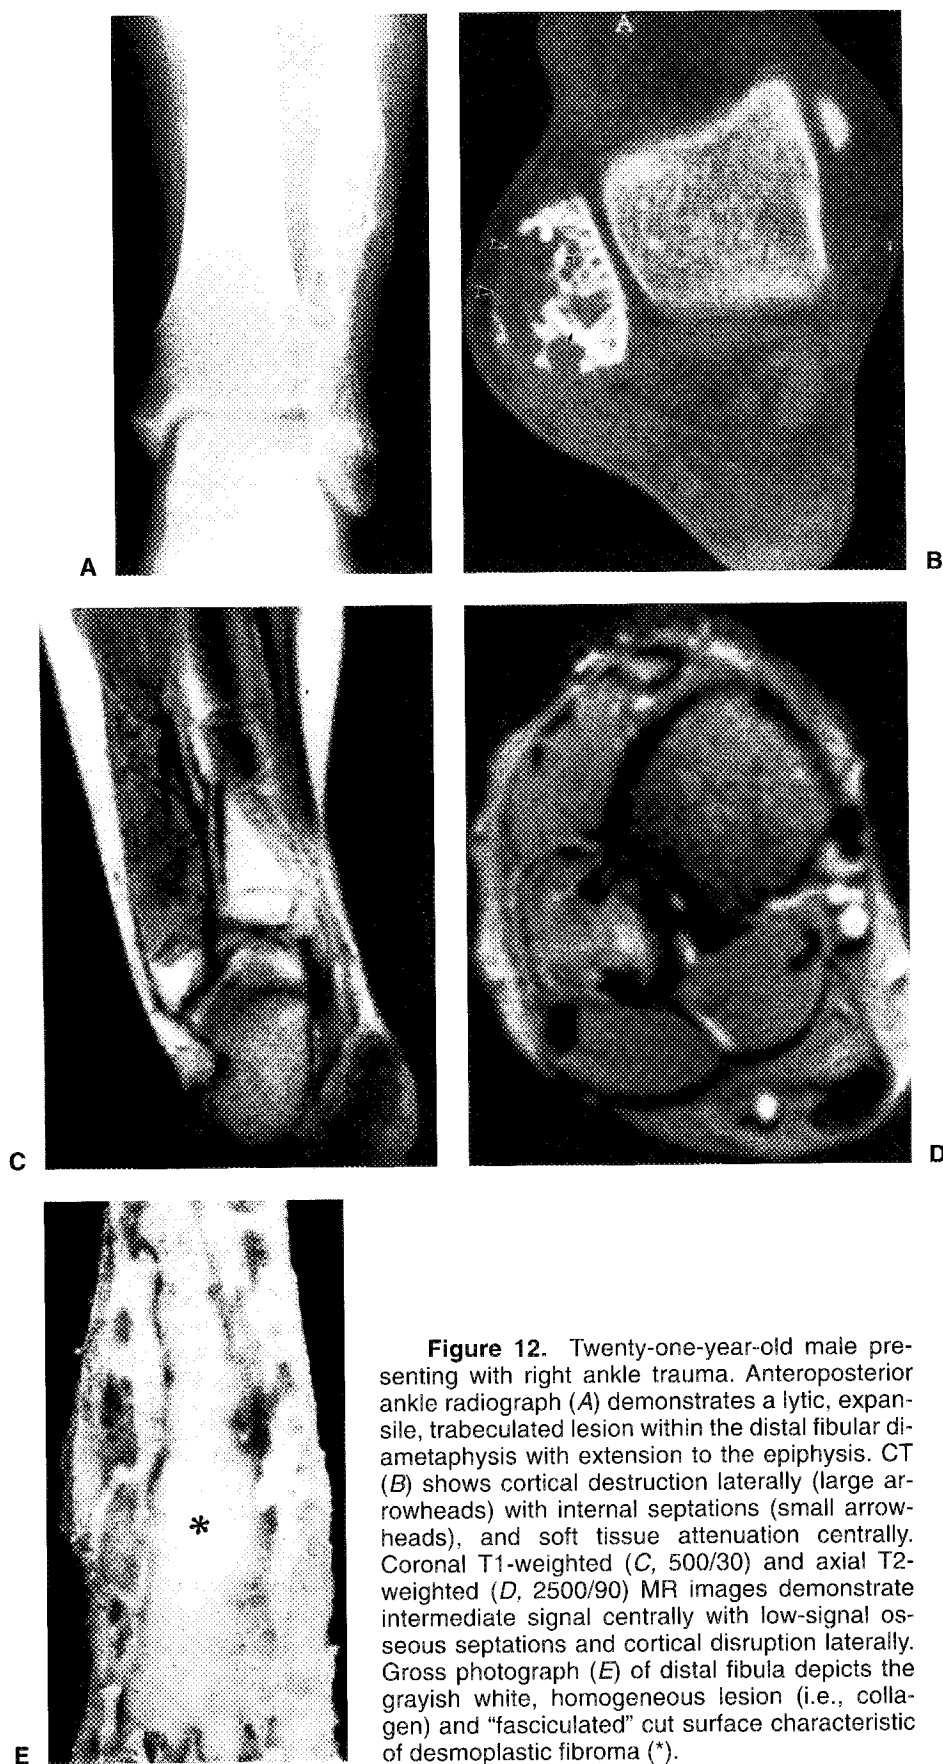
Twenty-one-year-old male presenting with right ankle trauma. Anteroposterior ankle radiograph (A) demonstrates a lytic, expansile, trabeculated lesion within the distal fibular diaphysis with extension to the epiphysis. CT (B) shows cortical destruction laterally (large arrowheads) with internal septations (small arrowheads), and soft tissue attenuation centrally. Coronal T1-weighted (C, 500/30) and axial T2-weighted (D, 2500/90) MR images demonstrate intermediate signal centrally with low-signal osseous septations and cortical disruption laterally. Gross photograph (E) of distal fibula depicts the grayish white, homogeneous lesion (i.e., collagen) and "fasciculated" cut surface characteristic of desmoplastic fibroma (*).
